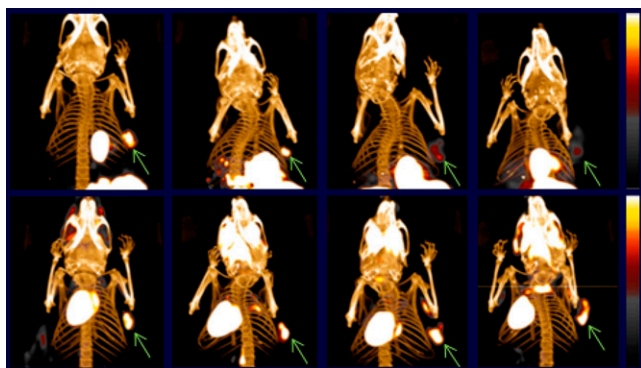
^{18}F -FES and ^{18}F -FDG PET/CT in MCF-7 xenografts demonstrates changes in estrogen receptor levels prior to changes in metabolism. Top row: ^{18}F -FES PET/CT with (left to right) vehicle, 0.05, 0.5, and 5 mg fulvestrant. Bottom: ^{18}F -FDG PET/CT with (left to right) vehicle, 0.05, 0.5, and 5 mg fulvestrant.
